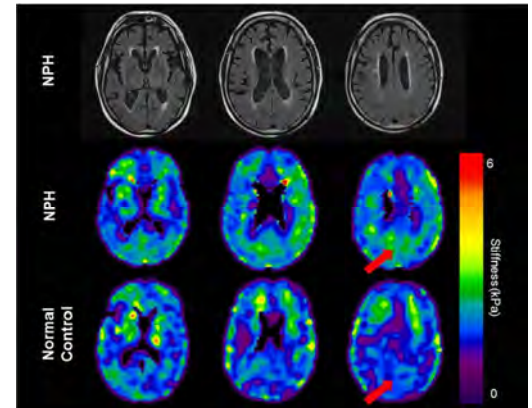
Results including a 67 yo male with NPH T2 FLAIR (1st row) and MRE (2nd row) compared with an age and sex matched normal control (3rd row). Findings show increased stiffness in the NPH subject compared with the normal control especially in the parietal and occipital regions (arrows).
